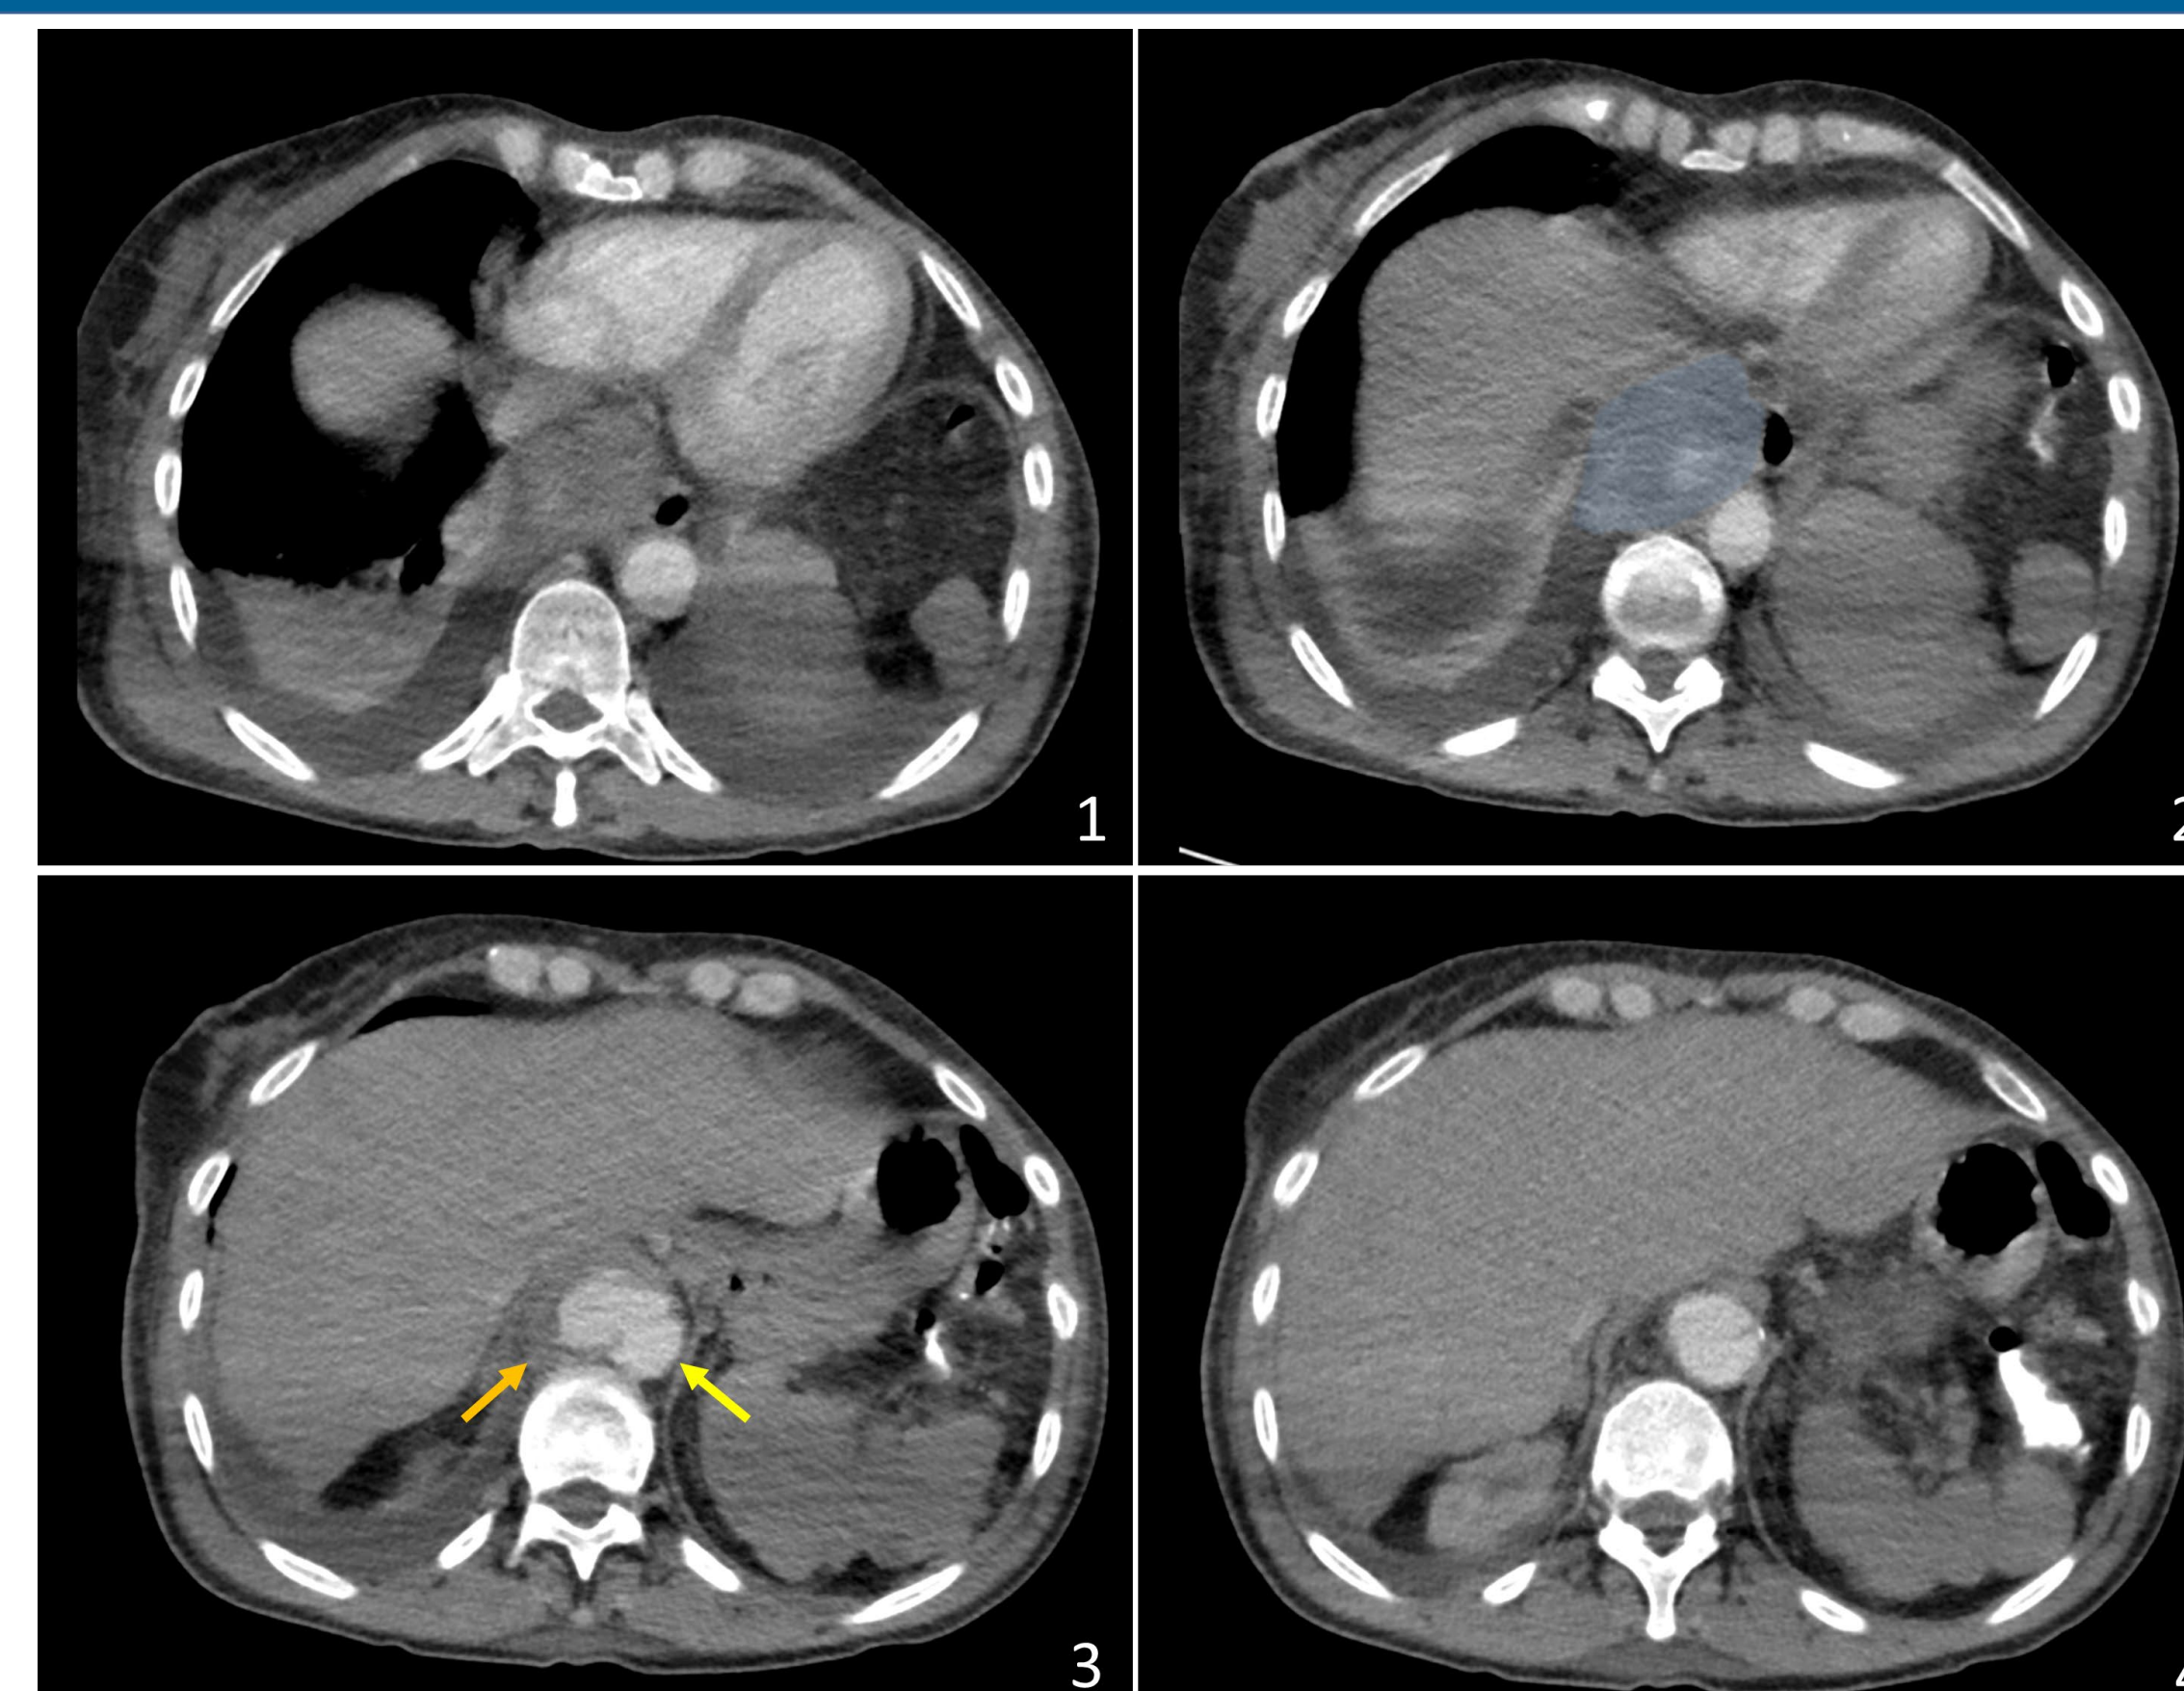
Contrast-enhanced axial CT images (1-4) of the descending thoracic aorta demonstrate a mixed density mass-like consolidation surrounding the aorta (blue outline in 2, orange arrow in 3). The aorta is aneurysmal and irregularly lobulated more inferiorly (yellow arrow in 3). Findings consistent with contained rupture or infectious aortitis.
